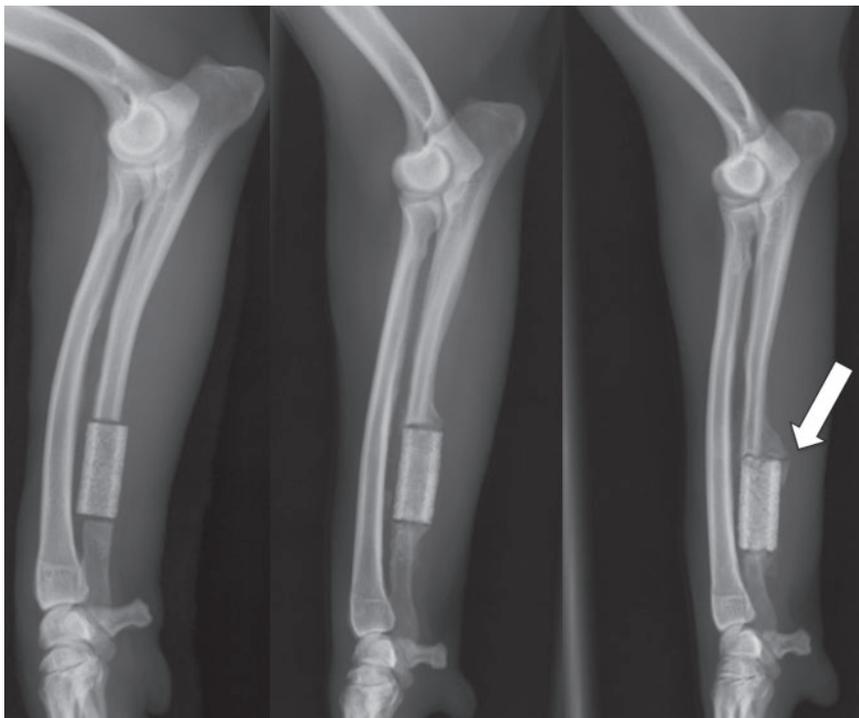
Medio-lateral X-rays. A) post operatively, B) post euthanization, intact scaffold with obvious bone formation, C) post euthanization, broken scaffold with obvious bone formation towards the scaffold.
